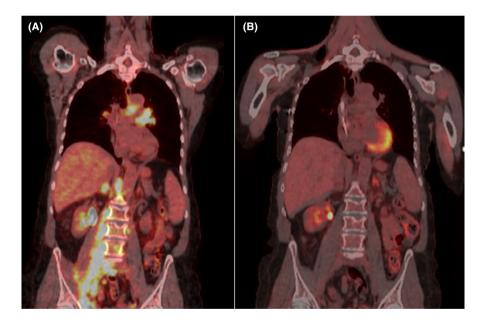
(A) FDG-PET scan demonstrating extensive hypermetabolic soft tissue activity involving the mediastinal bilateral hilar node chains with extensive confluent mesenteric, retroperitoneal, pelvic and inguinal lymph node disease. (B) Post-treatment FDG-PET demonstrating complete remission
